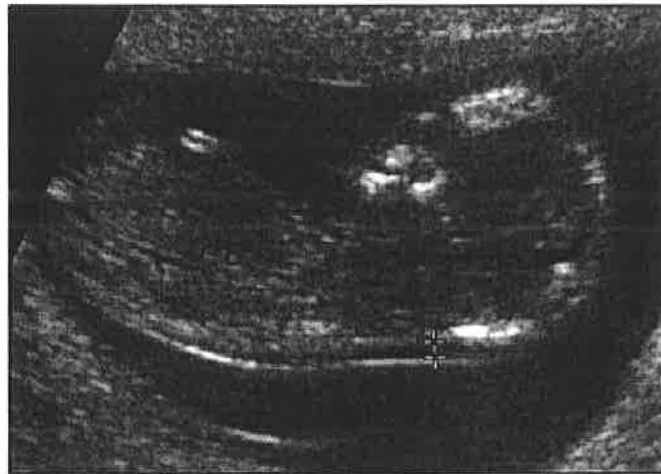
Ultrasound picture showing the nape region of a fetus (Nuchal Translucency/Early Anatomy Ultrasound).
